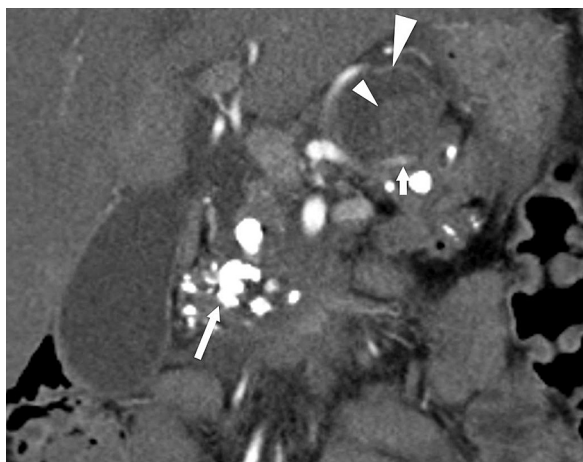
A 40-year-old female with chronic calcific pancreatitis presented with hemothorax. Contrast-enhanced computed tomography shows multiple intraductal and intraparenchymal calcifications in the head region (white arrow). Pseudocyst (large arrowhead) in tail region with hyperdense content within, suggestive of clot (small arrowhead). Note splenic artery (small arrow) traversing through the inferior wall of the pseudocyst. Digital subtraction angiography (not shown) confirmed a rent in the splenic artery which was treated by coil trapping.
